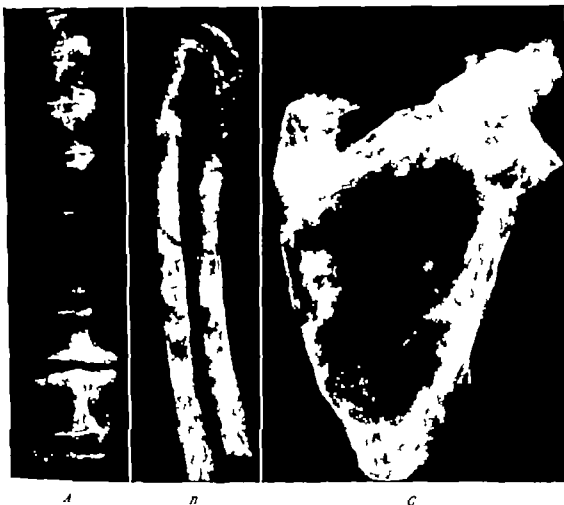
A B and C Roentgenograms from an autopsied case of prostatic carcinoma showing punched-out lytic defects (in the scapula) as well as the usual osteoplastic metastases (in the vertebral column and ribs.)
